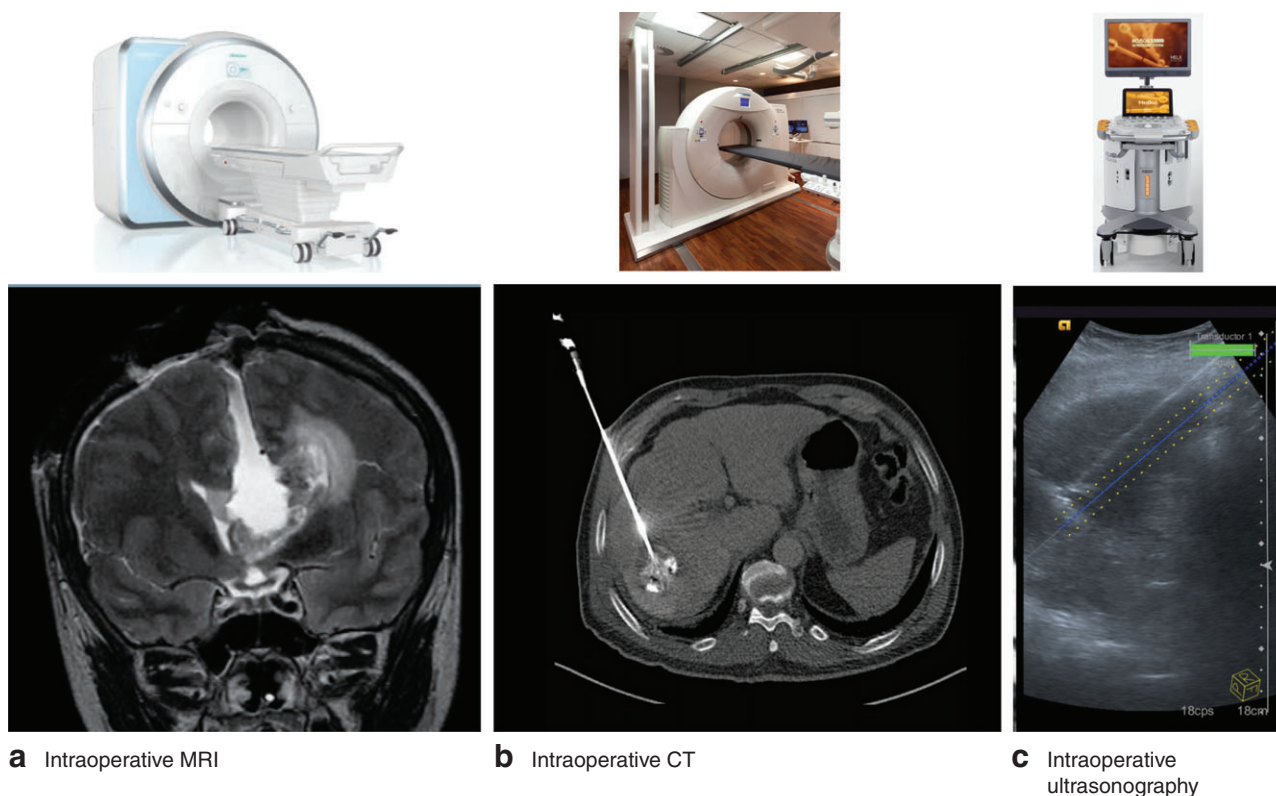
Conventional image-guided surgery systems and examples of image output: a intraoperative MRI, b intraoperative CT and c intraoperative ultrasonography
